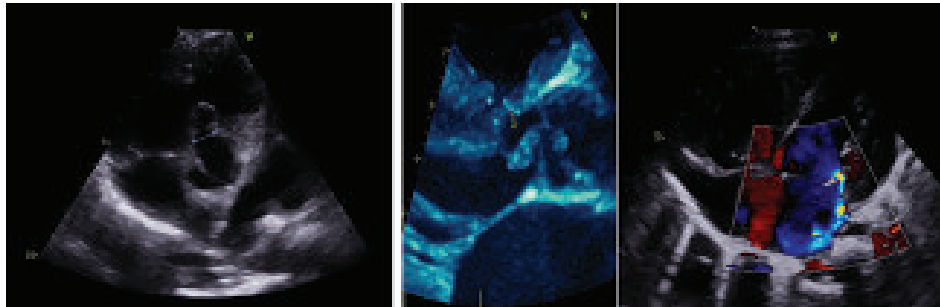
Preoperative Echocardiogram
